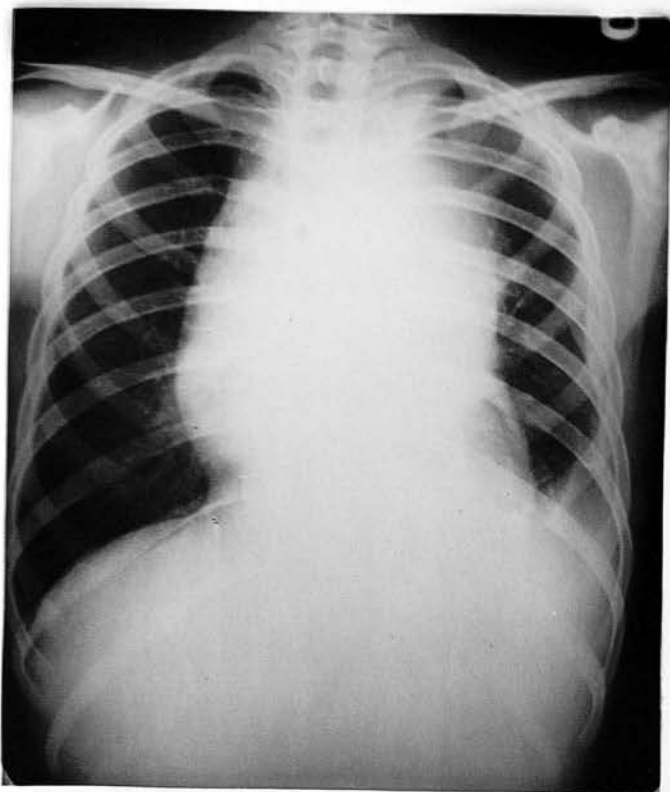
Case No. 14. Radiograph of chest (a) before treatment and (b) after treatment with 6-MP, showing clearance of pleural effusion and almost complete disappearance of mediastinal lymph nodes.
